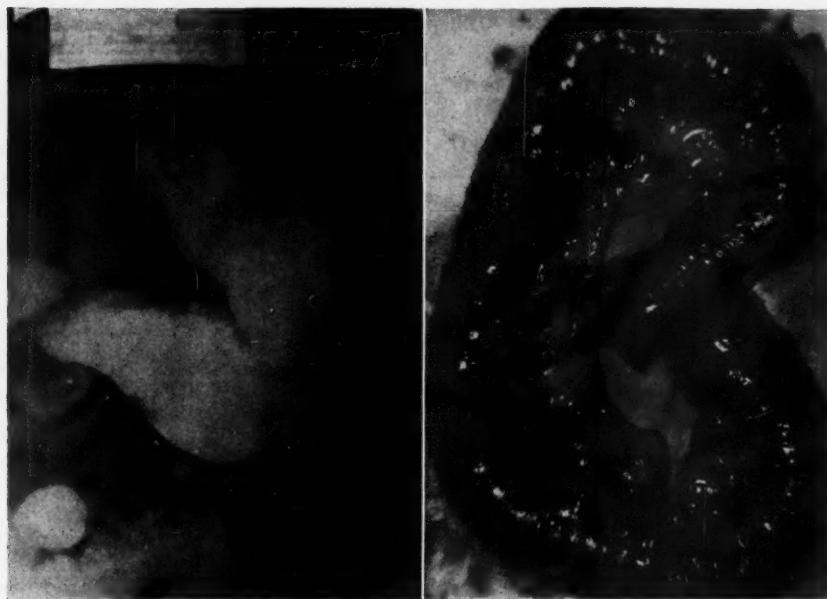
Case II. Upper gastrointestinal x-ray showing "cannon ball-shaped" jejunal diverticula.
